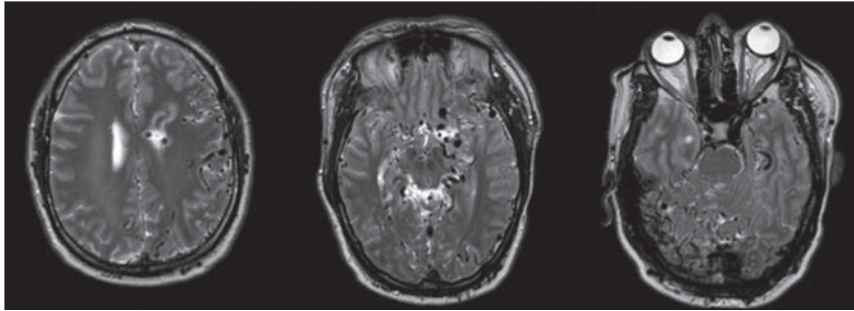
Axial T2 MRI showing abnormal serpiginous flow voids suggestive of Dural AV Fistula
